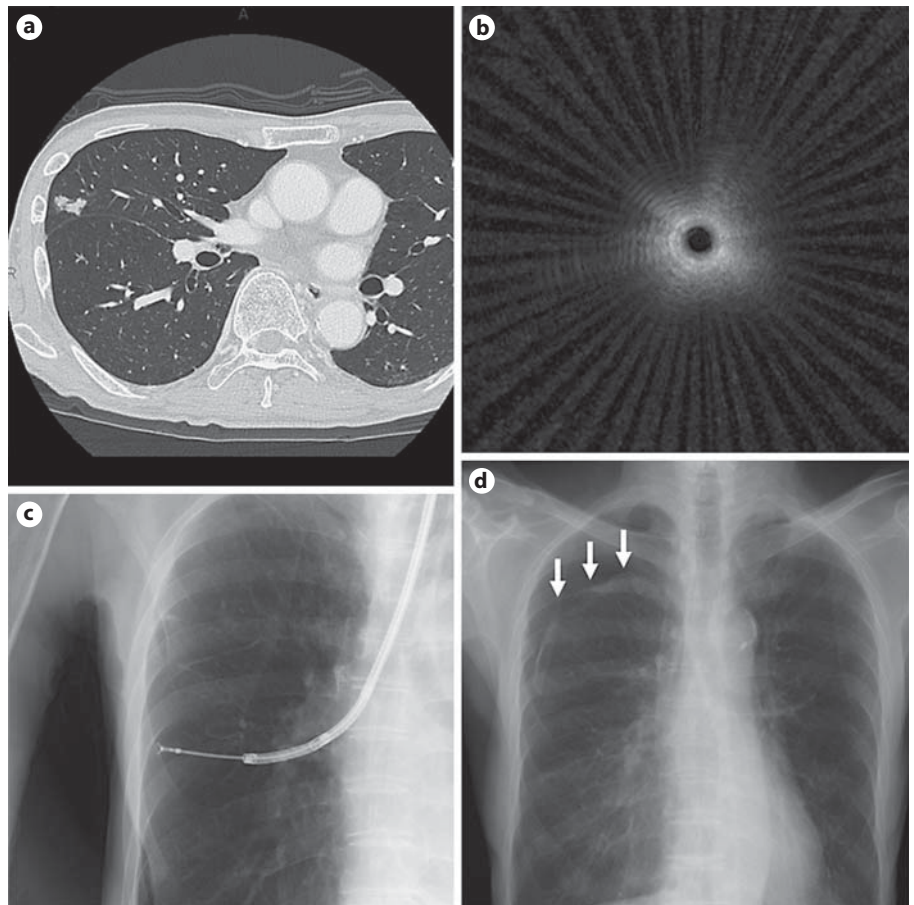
An 80-year-old male who developed pneumothorax after EBUS-GS. a A 17-mm solid nodule in the right S4 was adjacent to the costal pleura and major fissure. b The radial probe could not reach the nodule. c X-ray fluoroscopic image of EBUS-GS TBB. d Chest X-ray after the procedure revealed right pneumothorax (arrows).
